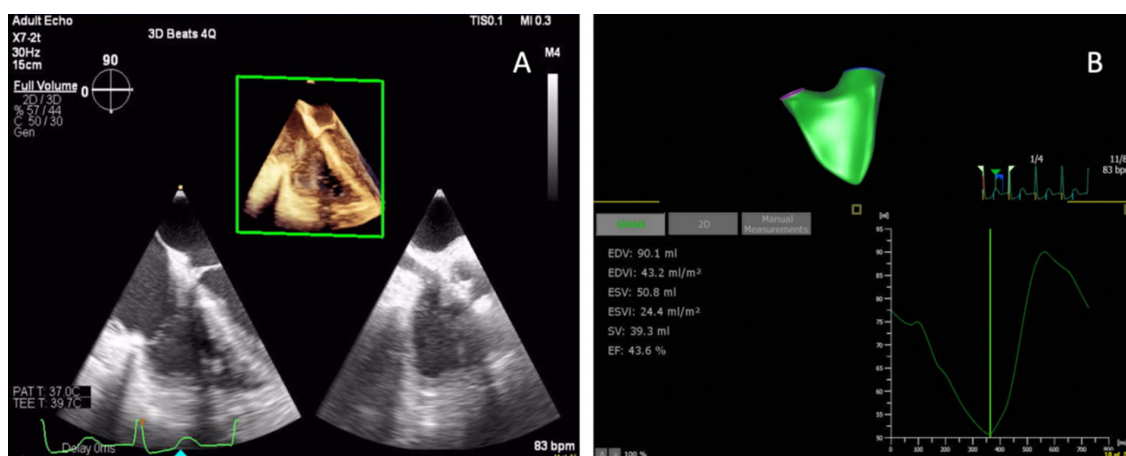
Transesophageal 3D multi-beat acquisition of the right ventricle (A); off-line analysis by dedicated software of right ventricular function (B)
